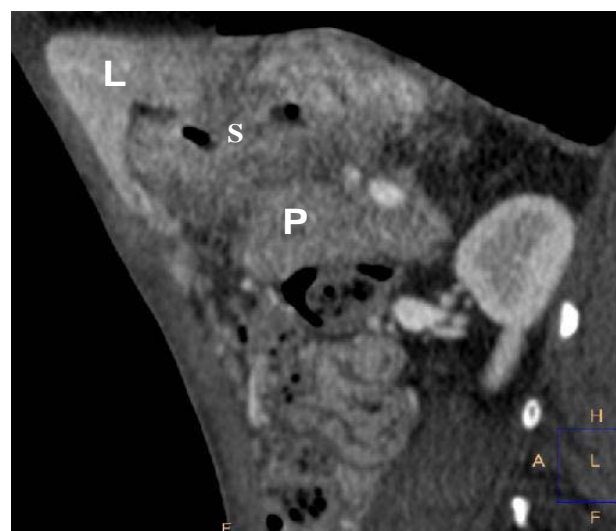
Post-chemotherapy abdominal CT scan disclosed a scirrhous gastric cancer (s) with invasion of liver (L) and pancreas (P).
